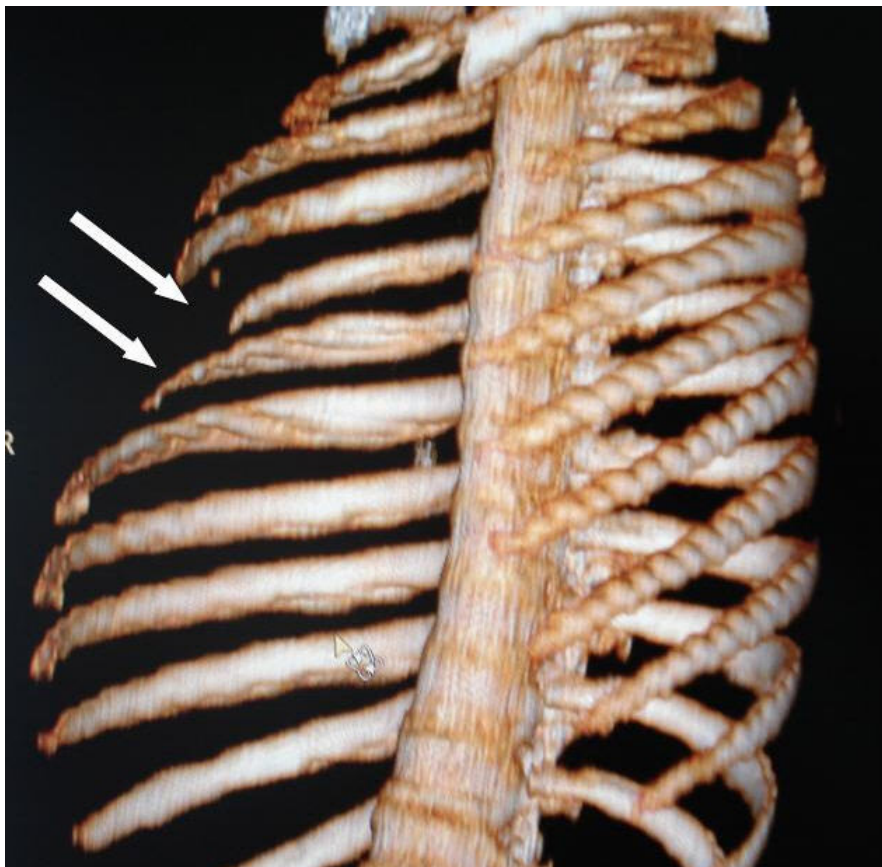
On volume rendering three-dimensional computed tomography (3D-CT) there were rib anomalies (arrows)
